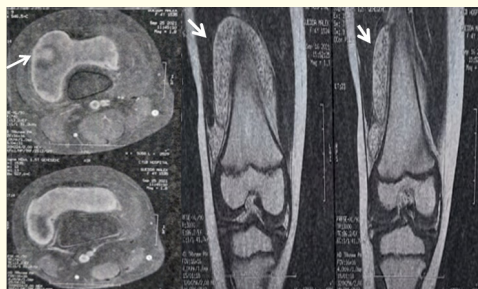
MRI: Synovitis of the right knee with 'rice bodies' hypointense T1 and T2
